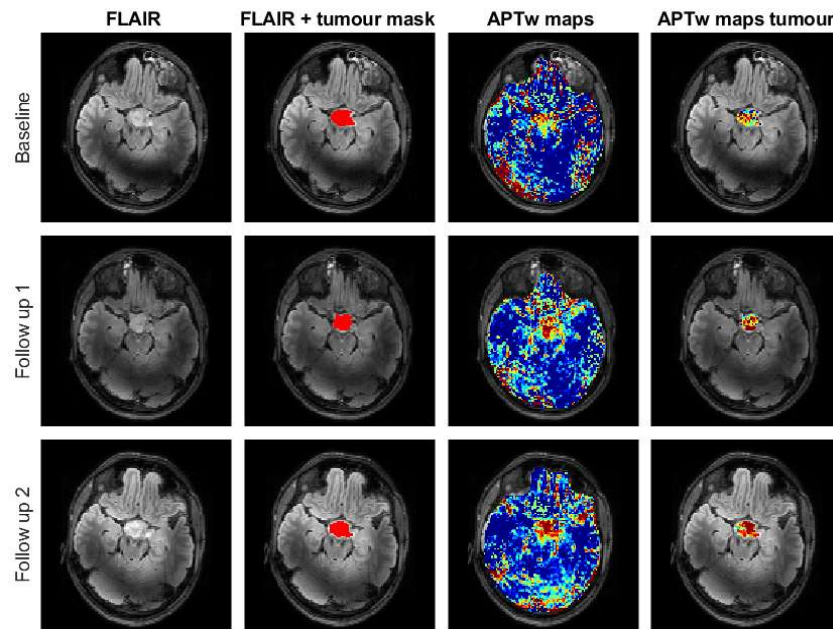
An example of the FLAIR, tumour mask, APTw maps quantified with MTRasym and the APTw values in the tumour of patient 1.
